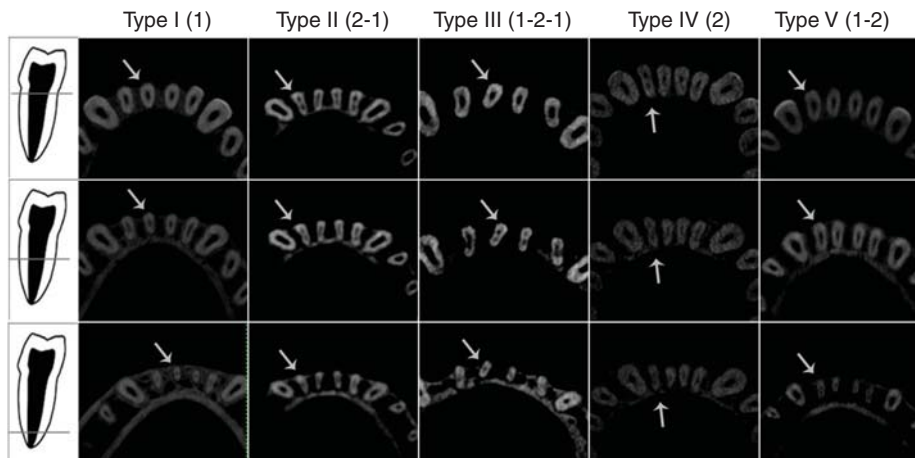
The CBCT images showing the five variants in permanent mandibular incisors.
